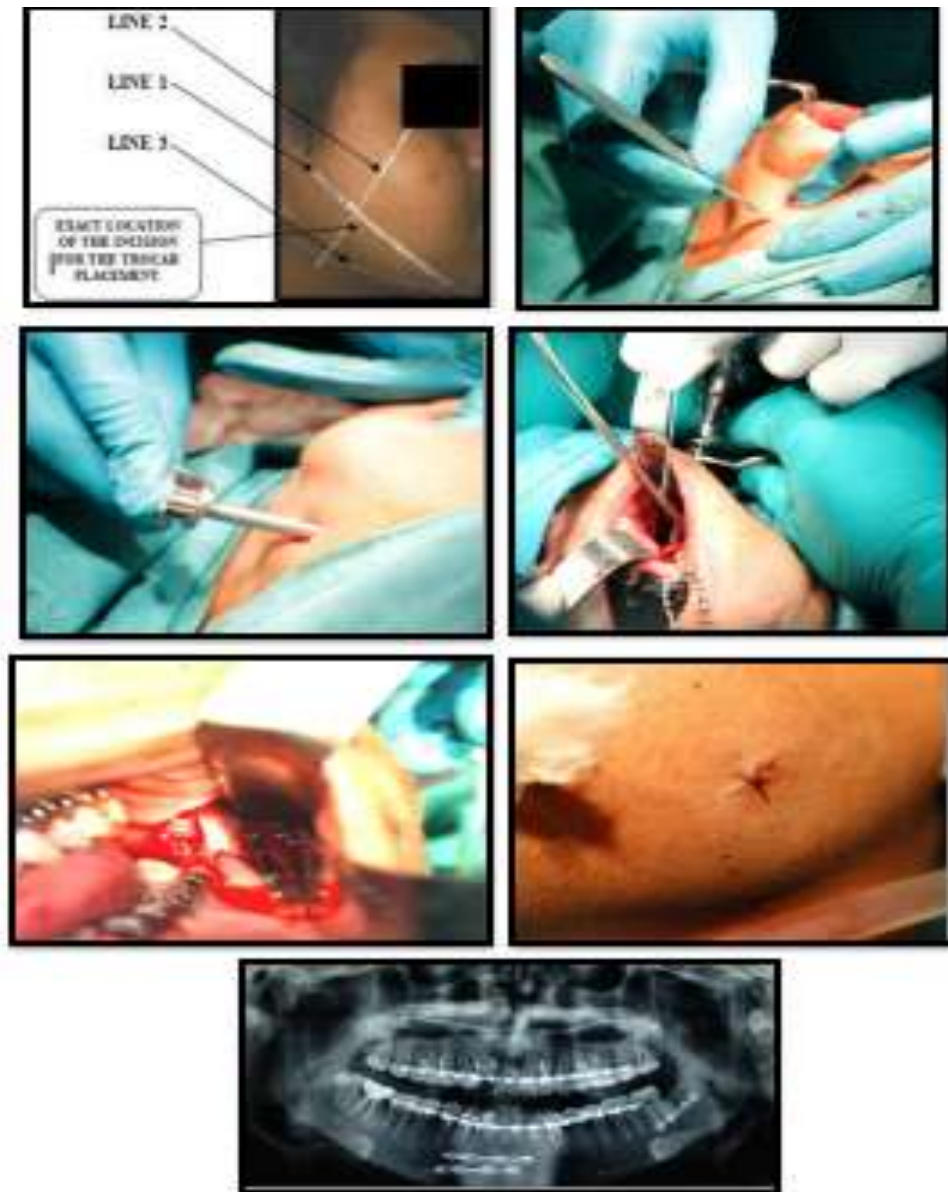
Transbuccal approach. A. Safe location for stab incision marked. B. A trocar was introduced into the operative site through the stab incision. C. Stabilized using the retractor. D. Plate fixation done through trocar. . Stab incision closure done. F. Postoperative radiograph
